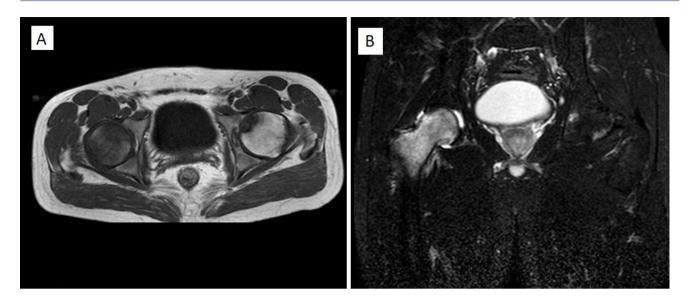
On T1-weighted axial MRI, the hypointensity was compatible with bone marrow edema in the right femoral head and subchondral cysts in the left femoral head. B. On fat-suppressed T2-weighted coronal MRI, joint effusion and significant bone marrow edema were present in the right hip joint.
